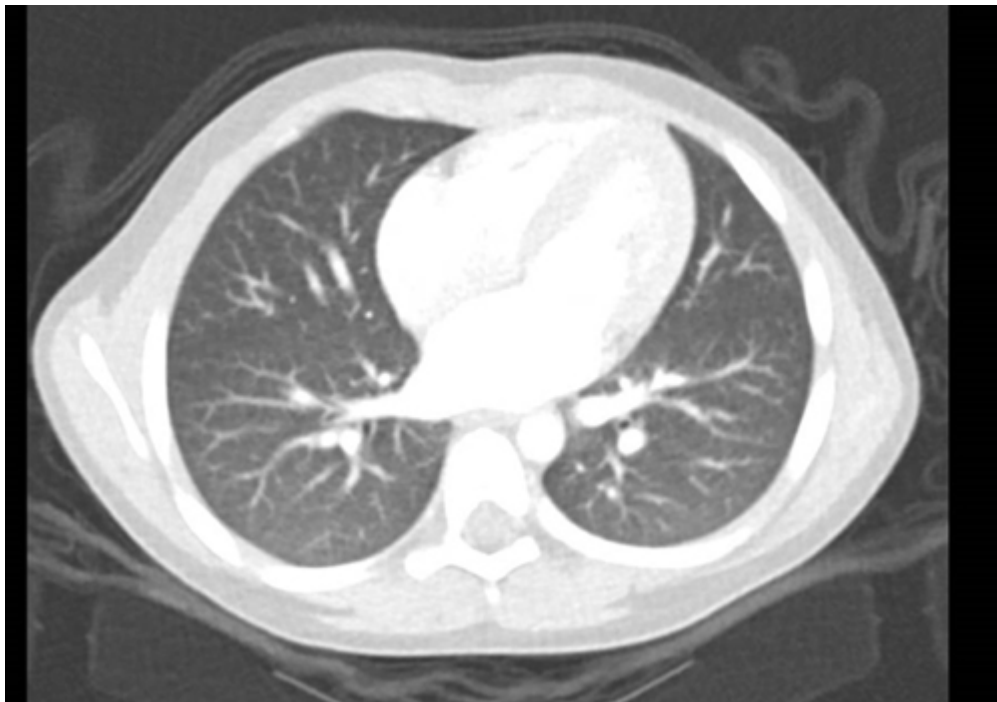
Normal CT thorax with no bronchiectasis, large airways thickening or mucus plugging, and no
